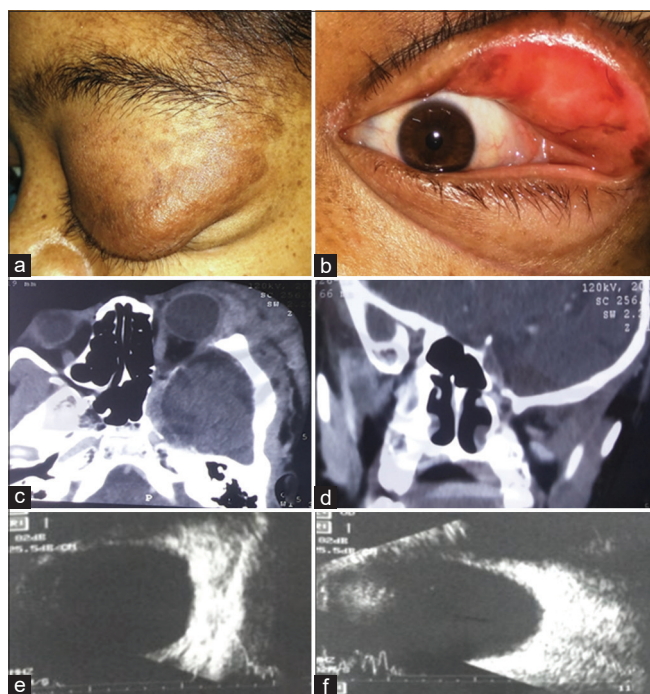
Patient presented with left upper eyelid plexiform neurofibroma (a). Globe hypotropia was seen with eyelid thickening (b). Contrast-enhanced computed tomographic scan revealed the presence of plexiform neurofibroma having extraconal extensions causing proptosis (c), dysplasia of the left sphenoid wing (c and d), and loss of volume of the temporal lobe (d). Right eye was normal on B-scan (e). Left eye had increased axial length (c and f)
